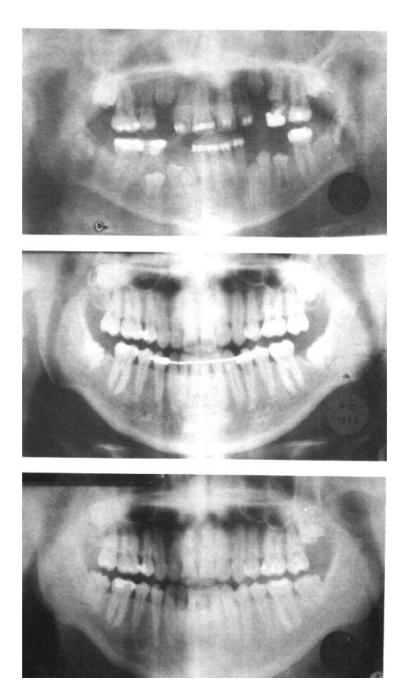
Case C, Class II, boy 12 years old at time of tooth bud removal. Final radiograph, age 18.
